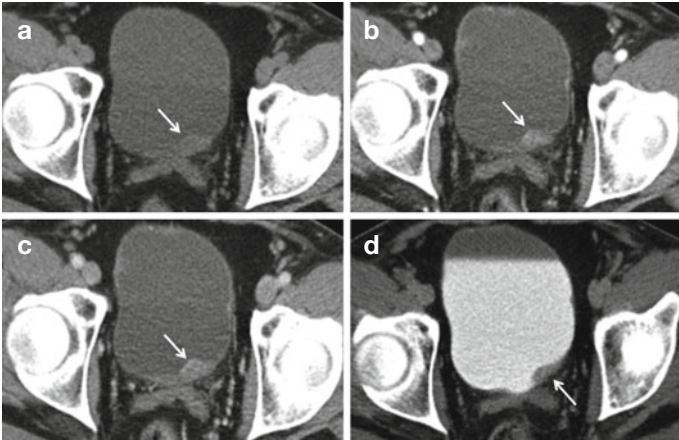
In basal conditions, CT scans can barely outline a solid mass (*white arrow*) protruding into the bladder (a). After intravenous administration of contrast medium, the lesion is well represented both during arterial and venous phase (b, c). During the urographic phase (d), the tumor appears as an image of “minus” compared to the hyperdense bladder which is full of contrast medium
